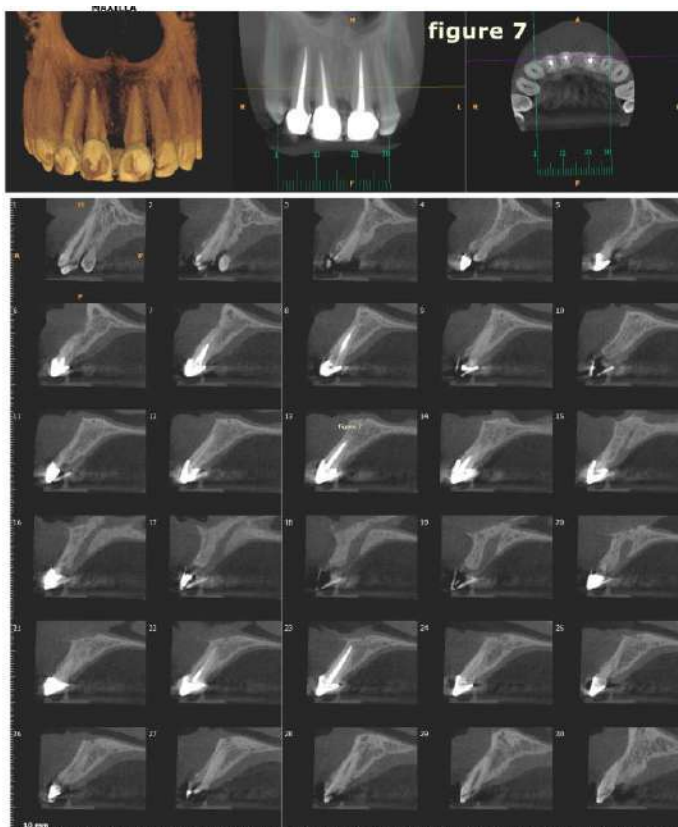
7. CBCT section evaluation showing no signs of resorption, FIG: 8. CBCT 3D reconstruction
